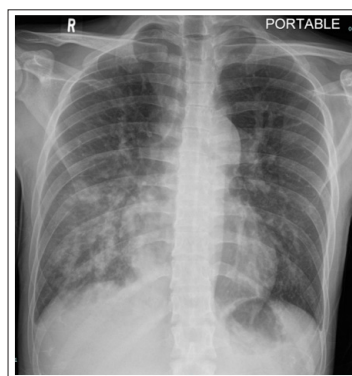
Initial Chest X-Ray Showing a Right Lower Zone Hazy Opacity
